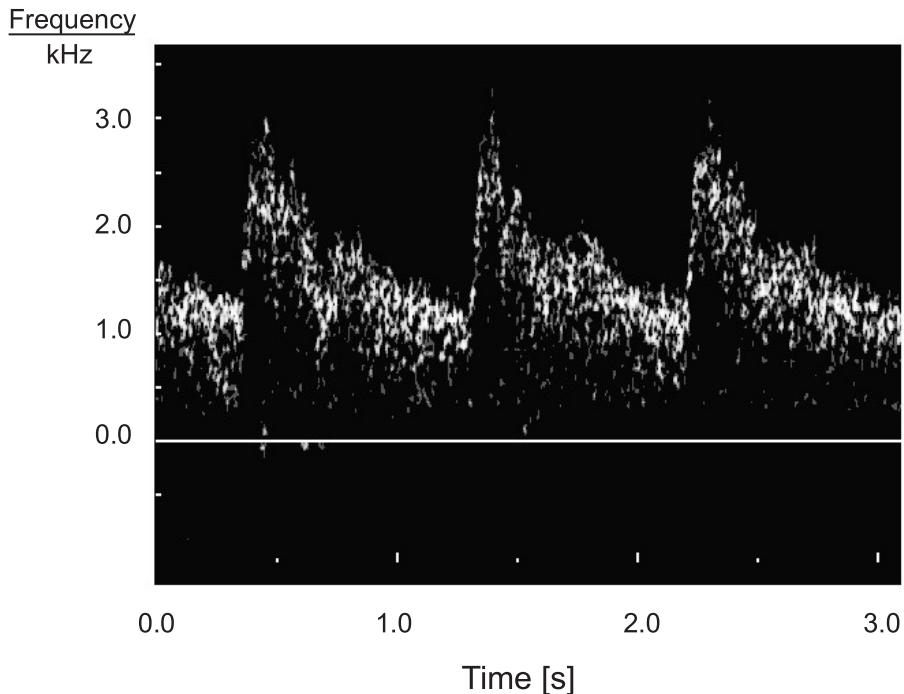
Arterial sonogram with time-frequency and Doppler shift [32]
